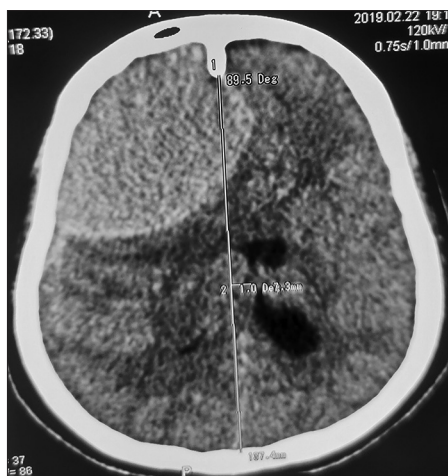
Computed tomography scan head showing large right frontal extradural hematoma with severe mass effect and subfalcine herniation. Note relative hypodensity of hematoma due to hypofibrinogenemia (43 HU)
